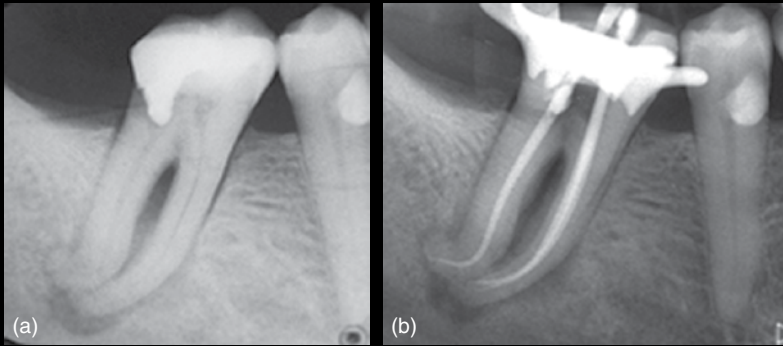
(a) Pre-operative radiograph. (b) Cone fit radiograph.
